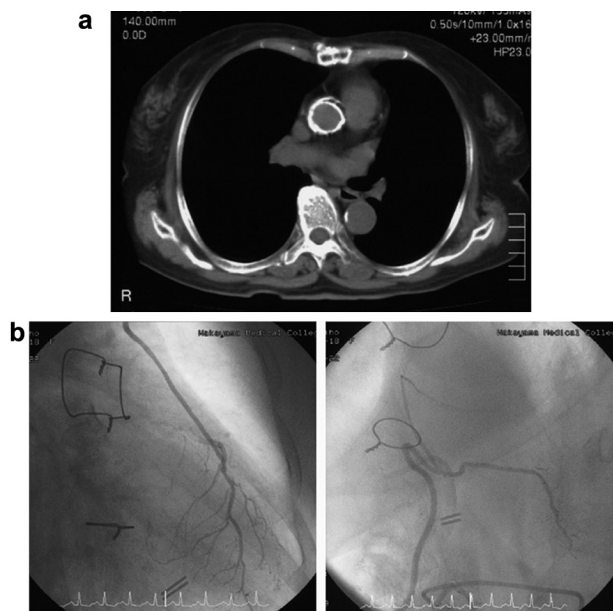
(a) Preoperative computed tomography demonstrated porcelain ascending aorta. (b) Preoperative coronary angiography demonstrated patent LIMA (left) and GEA (right) graft. LIMA: left internal mammary artery; GEA: gastroepiploic artery.
